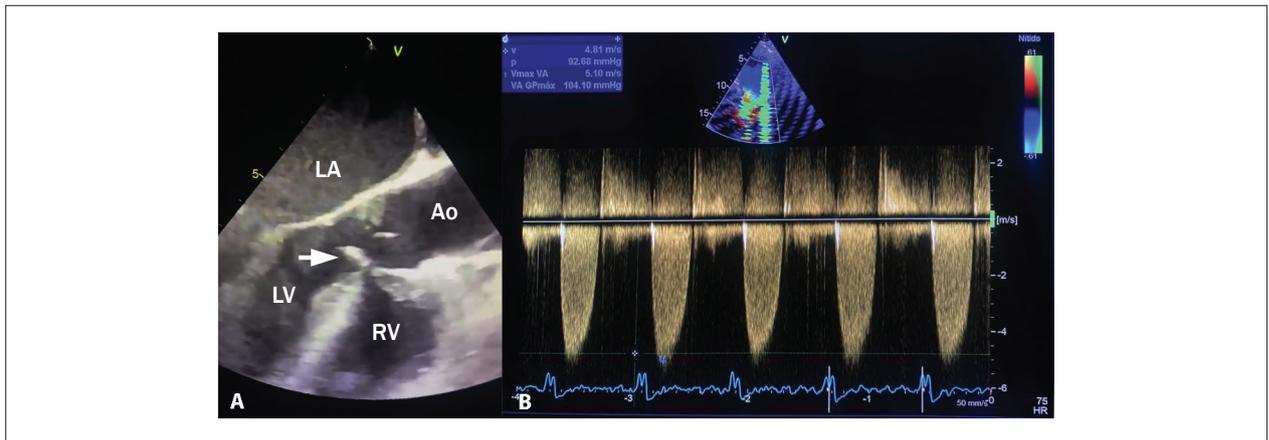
Transesophageal echocardiogram findings. (A) Subaortic membrane stenosis (arrow), fibromuscular ridge arising in the left ventricular outflow tract attached to the ventricular septum. (B) Doppler echocardiography shows aortic valve insufficiency and subvalvular stenosis. Ao: Aorta; LA: left atrium; LV: left ventricle; RV: right ventricle.
